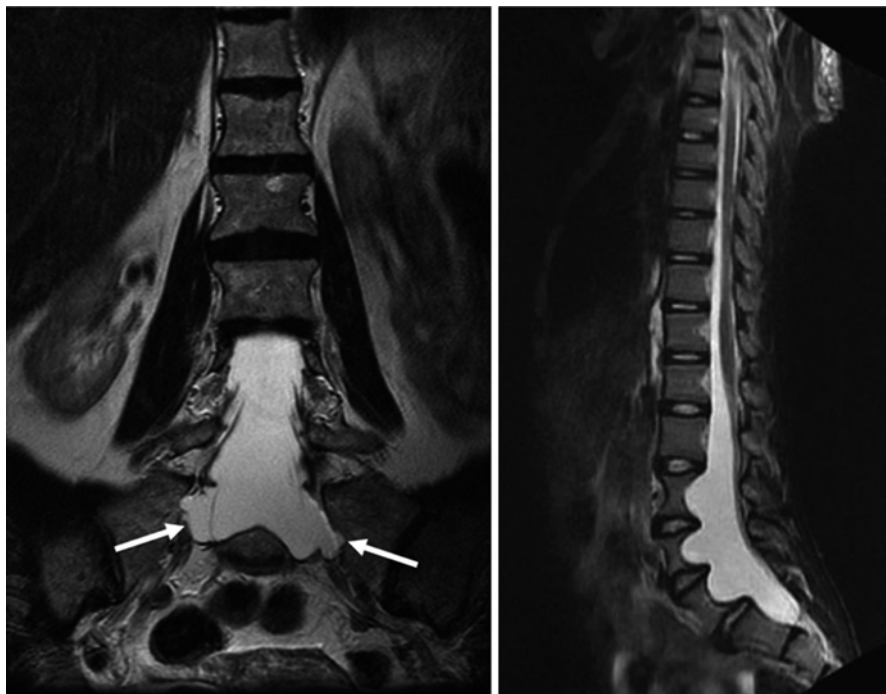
A T₂ weighted MRI scan of the lumbar spine showing dural ectasia in a patient with Marfan syndrome. The lateral extensions of dura around the S₁ nerve root sleeves are indicated in *white arrows*
